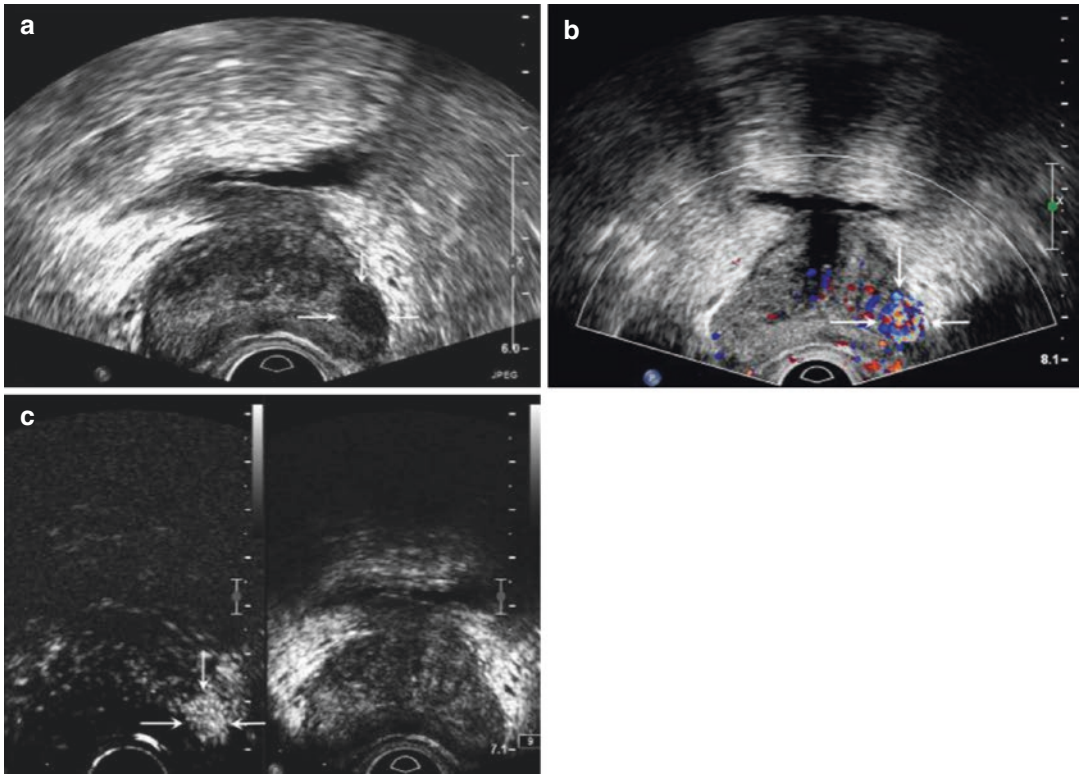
A 76-year-old patient with PSA of 4.1 ng/mL. (a) The image with gray scale demonstrates a hypoechoic area in the left median region (*arrows*). (b) The color Doppler image demonstrates an increasing vascular flow in the region (*arrows*). (c) The CEUS image evidences a significant enhancement in the lesion, which shows irregular morphology, 17 s after the administration of the contrast medium. The final pathologic exam evidenced BPH
